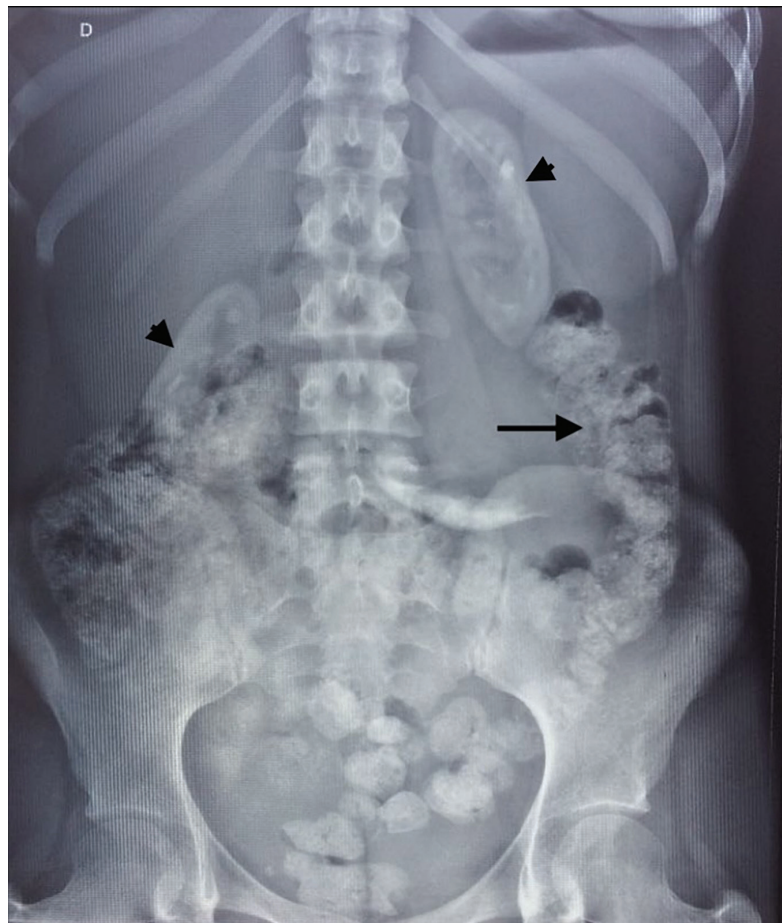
Plain abdominal x-ray showing colonic calcifications (arrow) and nephrocalcinosis (arrow head) in a patient diagnosed with primary hyperoxaluria type 1.
